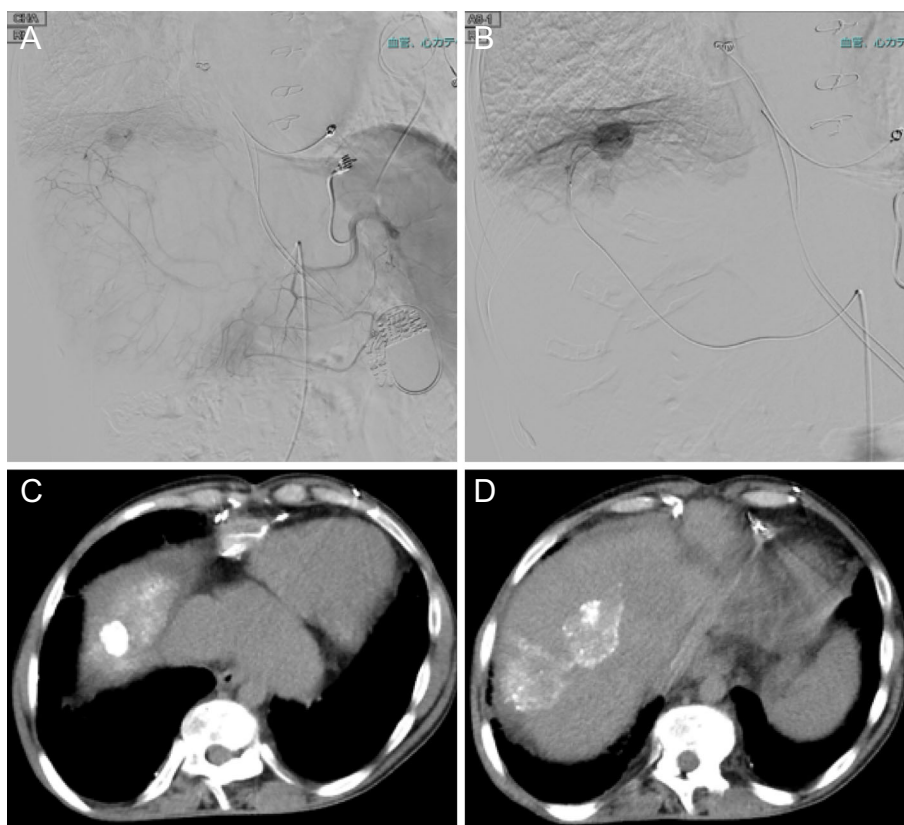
Abdominal angiography showing sub-diaphragm hepatocellular carcinoma at segment 8 (A, B). Non-contrast-enhanced computed tomography after transarterial chemoembolization (C, D).
